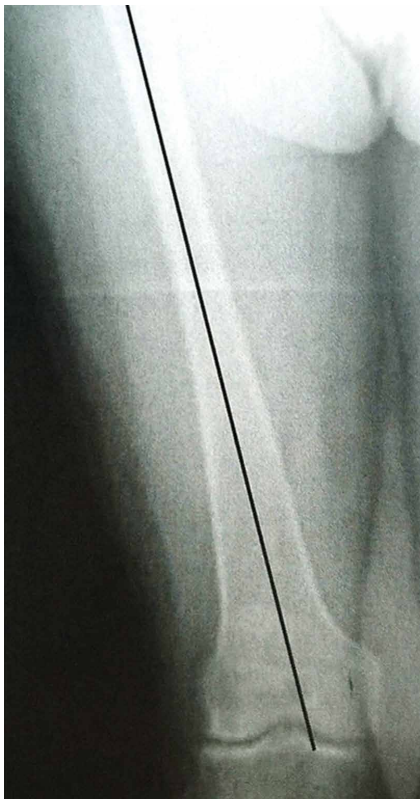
The entry hole for intramedullary alignment devices should be templated on a preoperative roentgenogram. Its placement will affect the valgus angle chosen to reproduce the desired distal femoral resection angle.
